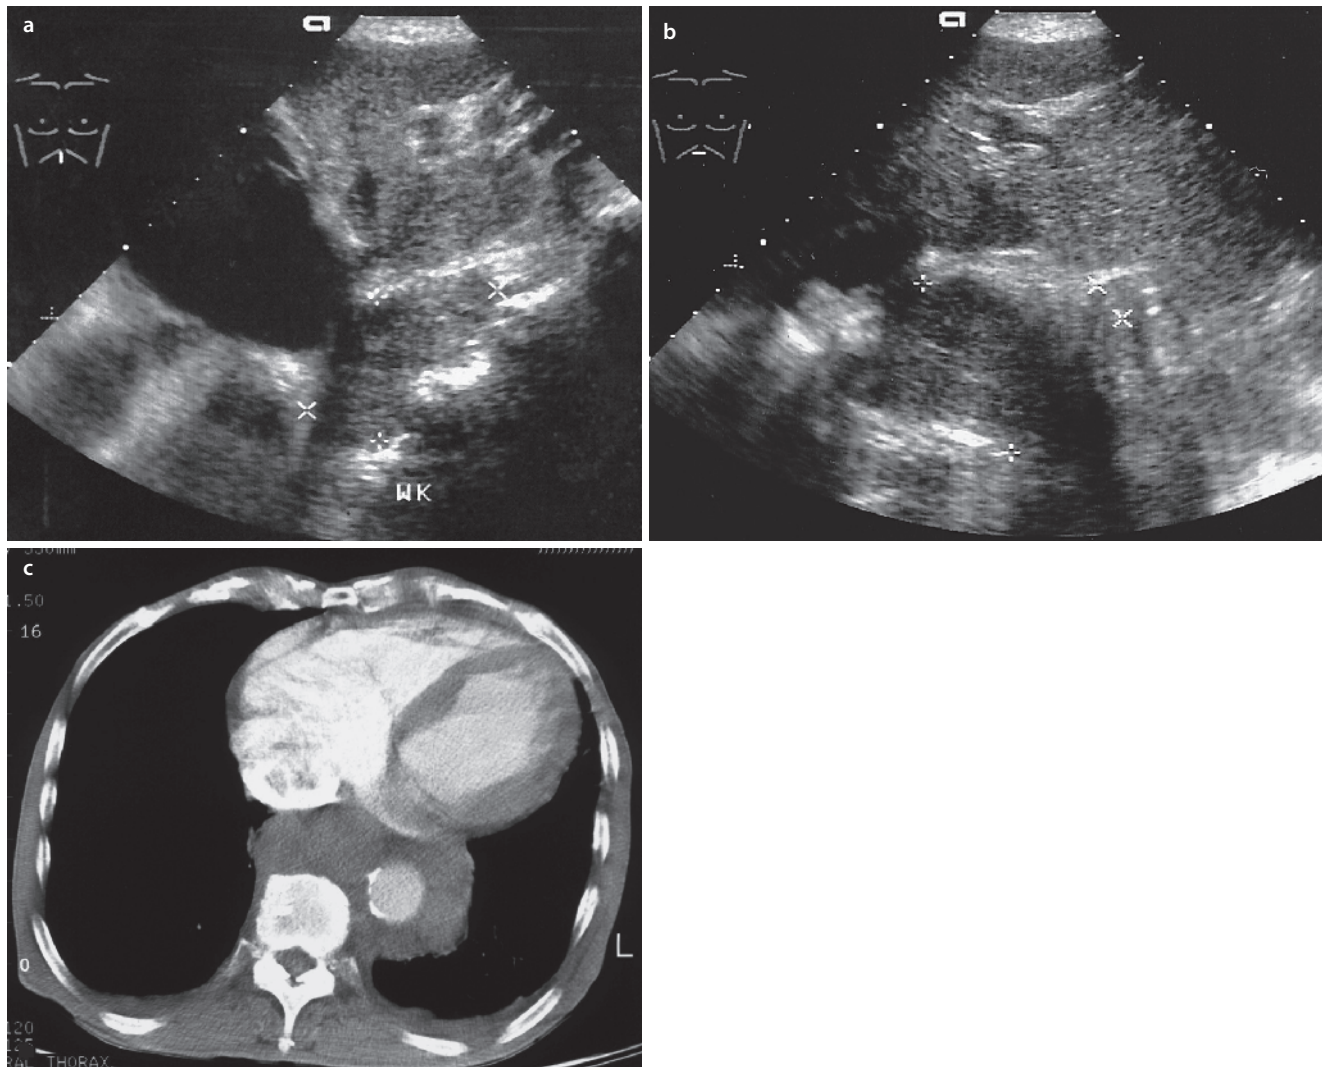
Extensive esophageal carcinoma. a Clinical dysphagia. Endoscopic distal esophageal stenosis. No tumor could be established with certainty by biopsy. Sonography with infrasternal, sagittal section of the tumor formation lying ventrally to the spinal column (posterior mediastinum). *WK* vertebral body. b Tumor (*crosses*) located
